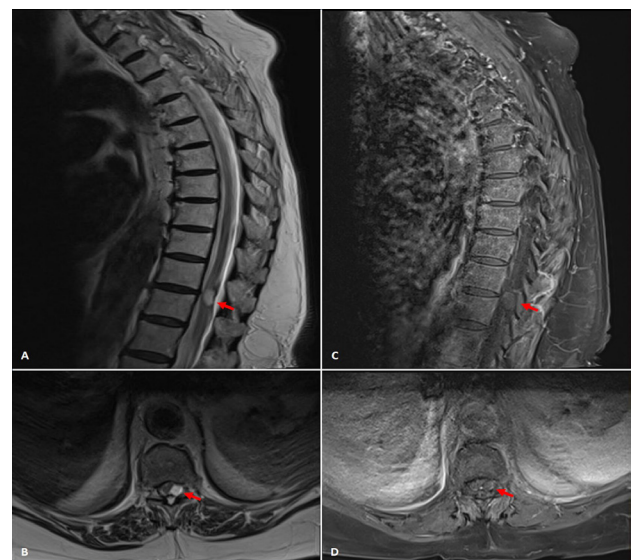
(A-D) Preoperative MRI. (A) Sagittal and (B) Axial T2-weighted MRI sequence demonstrating the interval growth of the intradural extramedullary lesion (red arrows) At the level of T10-11. (C) Sagittal and (D) Axial T1-weighted post gadolinium MRI sequence demonstrating lack of enhancement of the lesion (red arrows).
